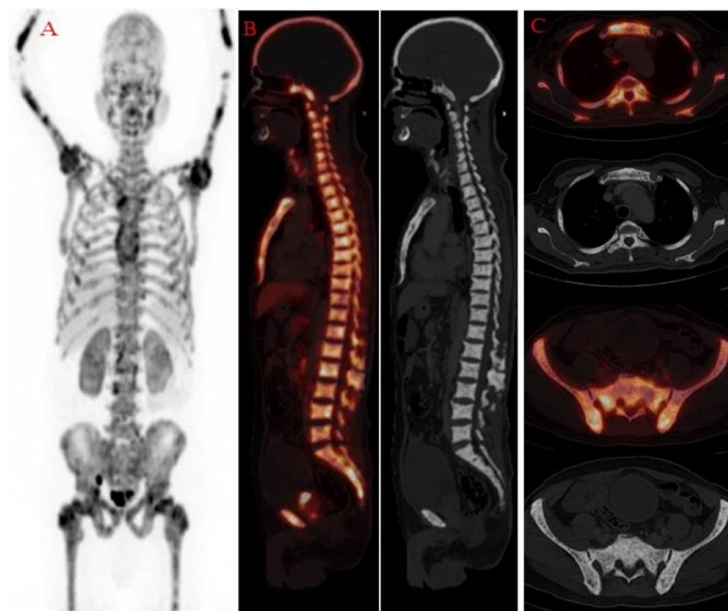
¹⁸F prostate-specific membrane antigen (PSMA) positron emission tomography/computed tomography (PET/CT) scan maximum intensity projection image (A) showing generalized increased patchy tracer uptake throughout the skeleton and reduced tracer uptake in salivary and lacrimal glands, spleen, proximal small gut, and kidneys mimicking a metastatic superscan. The corresponding CT scan showed the sclerotic lesion in the visualized axial and appendicular skeleton with increased radiotracer on PET/CT in sagittal (B) and transaxial sections at the level of the thorax and pelvic regions (C), respectively. Superscan of malignancy is a well-known phenomenon on Tc-99m methylene diphosphonate bone scintigraphy. There is increased patchy/diffuse uptake of radiotracer throughout the skeleton with faint/non-visualization of the kidneys (1). Superscans are often seen in benign conditions (including hyperparathyroidism, renal osteodystrophy and Paget's disease), myeloproliferative disorders (including leukemia lymphoma and Waldenstrom's disease), and malignancies (like prostate, breast and lung) (2,3). Superscans indicate advanced stages of disease and have poor prognoses (4,5). ¹⁸F PSMA PET/CT has significant value in staging (6), detection of biochemically recurrent prostate cancer (7), risk stratification, and evaluation of distant metastases in prostate carcinoma (8).
